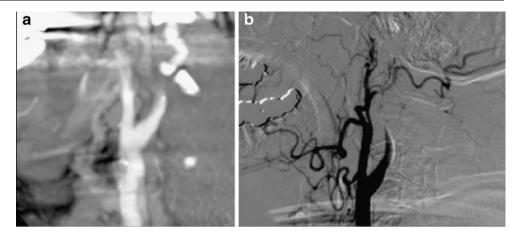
Patient with carotid artery dissection: Reconstruction of the CTA shows a flame signs, confirmed by DSA
